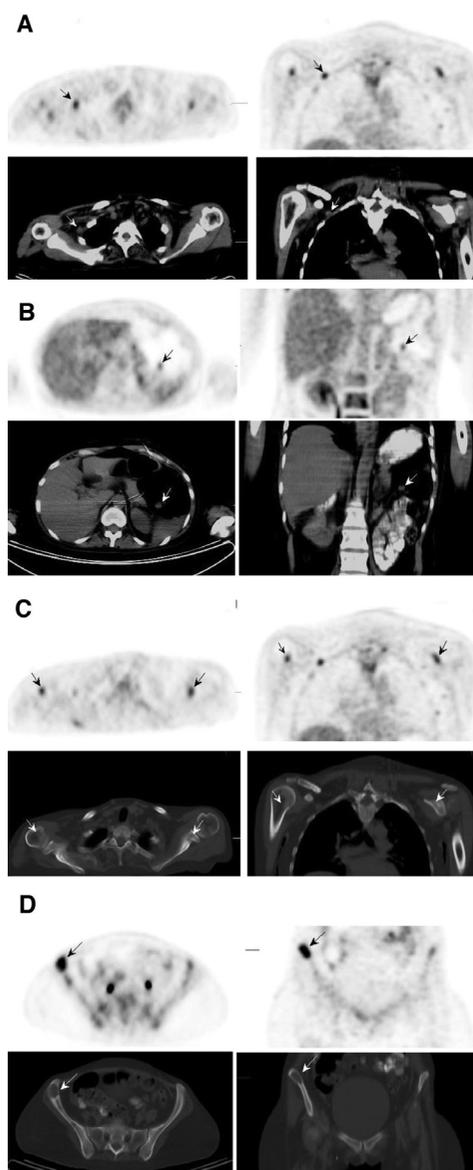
PET/CT images performed within the 1st postoperative year of a patient with primary tumor localized at the foot with a negative sentinel lymph nodes biopsy, showing right axillary lymph node metastasis (A), mesenteric metastasis (B), and bone metastasis (C and D)
